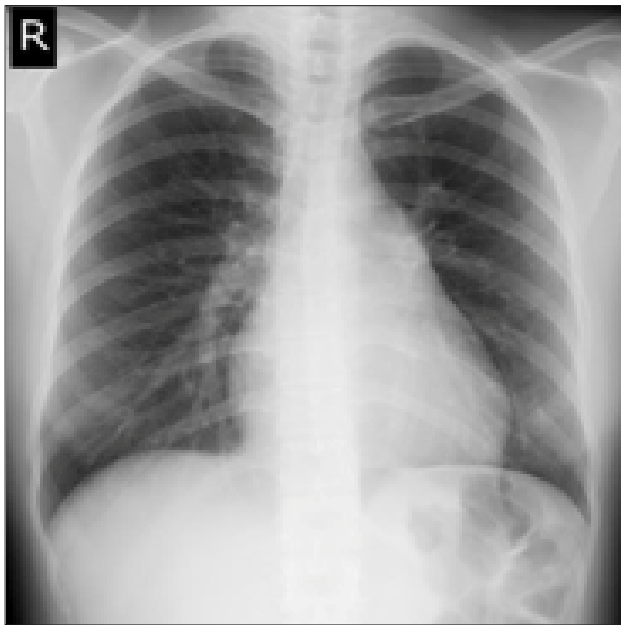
Chest radiograph showing cardiomegaly, slightly increased pulmonary vascularity and slightly prominent main pulmonary artery.
